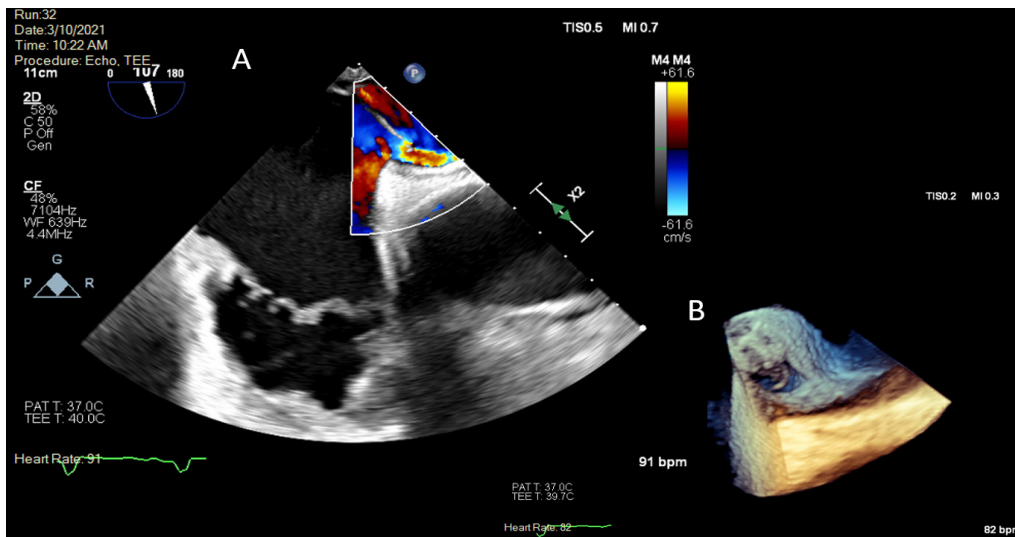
(A) TEE in midesophageal 4-chamber view (107 degrees) with focus on the inter-atrial septum and color Doppler showing a patent foramen ovale (PFO) with right-to-left shunt as well as complete resolution of intra-cardiac thrombus. (B) 3D TEE showing the PFO.
